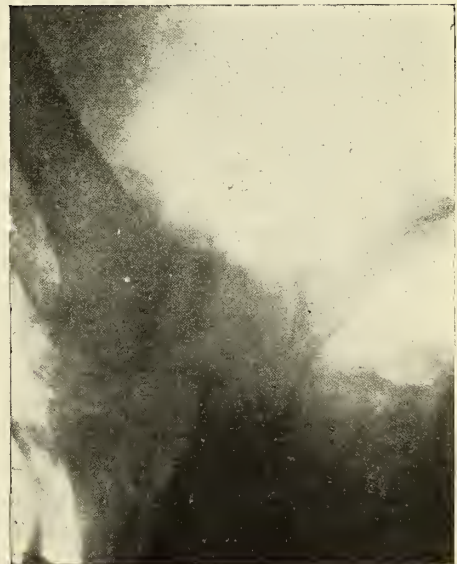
X-ray through plaster Paris spica applied with leg in abduction showing correction of deformity.
